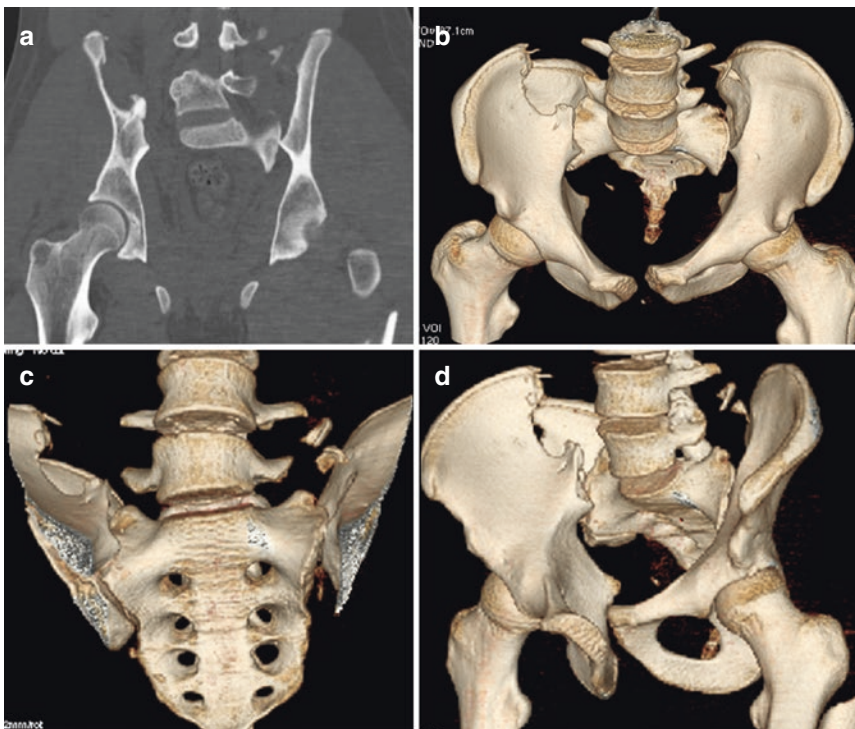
(a–d) “Vertical shear” (VS) fracture. (a) CT MPR coronal view demonstrates bilateral sacroiliac fractures; CT 3D (VR) reconstruction AP view (b) and lateral view (d) show better sacroiliac fractures and dislocation;
